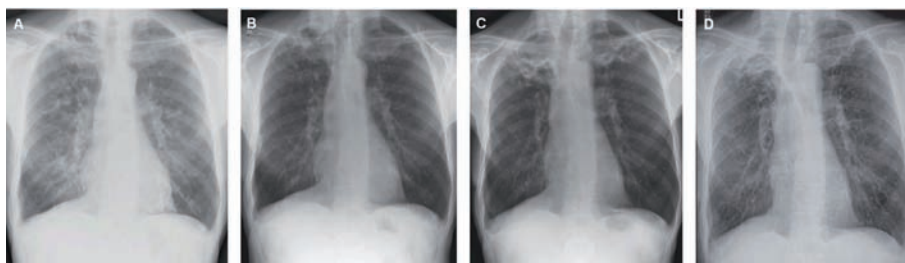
The patient's chest X-rays
